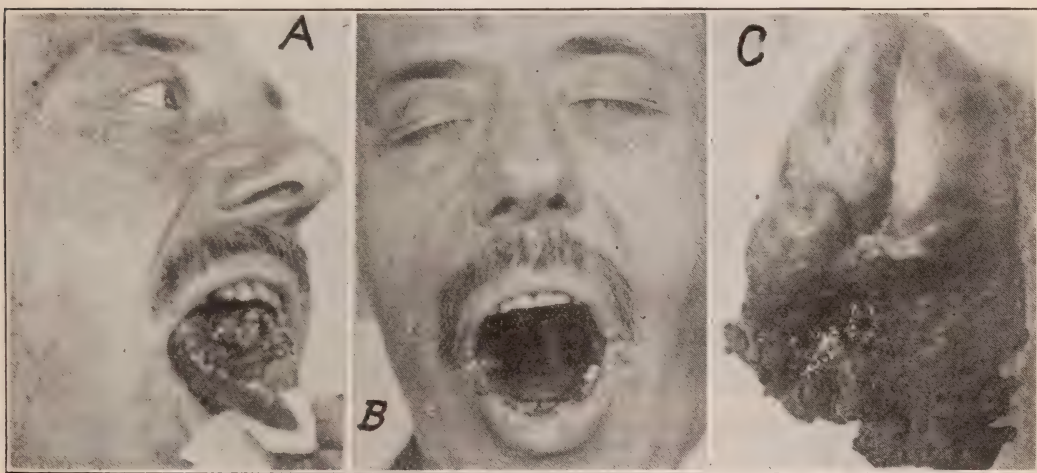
A, advanced squamous cell carcinoma of the tongue of four months' duration in a man, aged 46, referred by Drs. John B. Deaver and Walter Ziegler, of Philadelphia. The cervical glands were involved and treated by the roentgen ray. The tongue was amputated at the line of the tonsils by the electrothermic coagulation method under general anesthesia, without hemorrhage. Little pain or discomfort followed the operation. B, result after electrothermic treatment. No local recurrence in two months. This photograph is shown to demonstrate the practicability of amputation of the tongue by the electrothermic method. C, tongue in another case immediately after amputation by this method. Note coagulated area at distal end.
